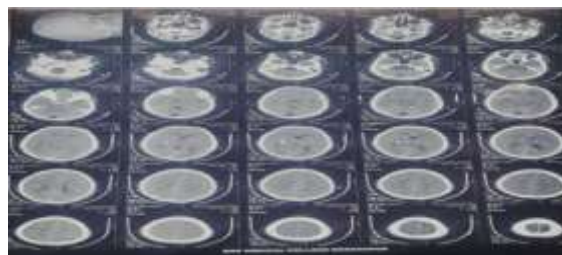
NCCT BRAIN showed "Axial sections of non-contrast computed tomography scan of brain shows a hyperdense focus of bleed attenuation in right lentiform nucleus. Surrounding hypodense rim is seen representing edema. Right basal ganglia hemorrhage".
